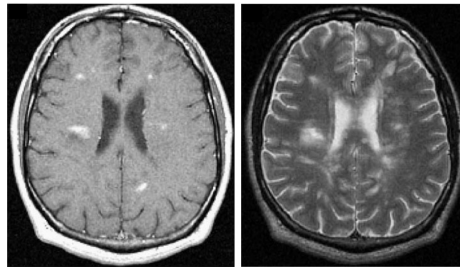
T_1 (left) and T_2 (right) weighted MR images of human brain.
